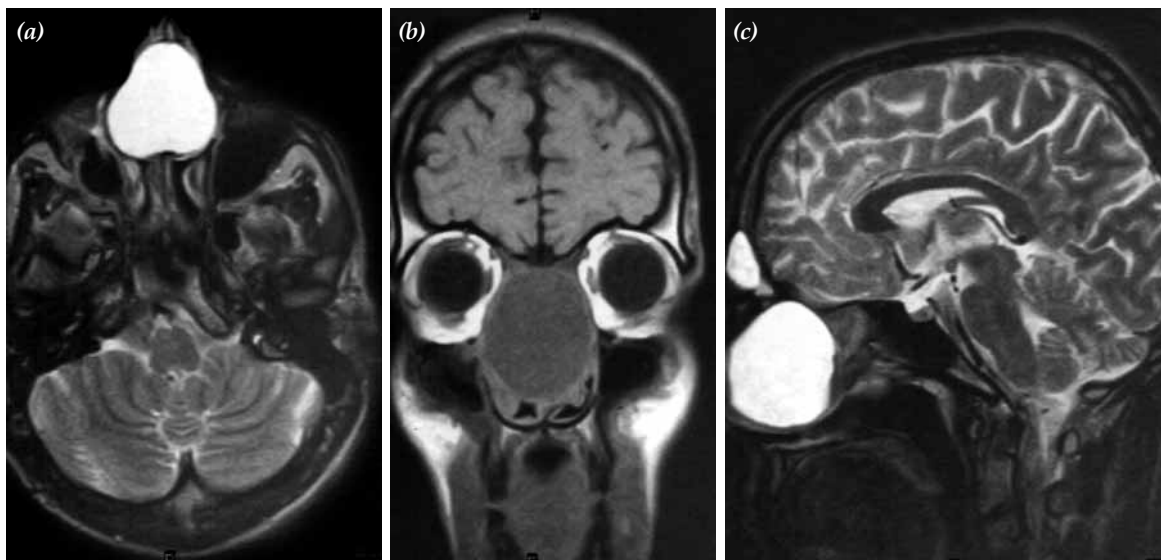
MR images in a 25-year-old patient who had large nasal septal cyst. (a) Axial T2-weighted turbo spin-echo MR image shows hyperintense signal in the nasal septum. (b) Coronal T1-weighted spin-echo MR image shows hypointense signal in the nasal septum. The nasal cavity completely filled up with cyst and expanded on turbinates and ethmoid sinus. (c) Sagittal T2-weighted turbo spin-echo shows hyperintense signal in the nasal septum. The cyst has straight border, homogeneous content and 4x4x3 cm in size.
